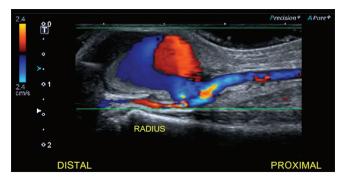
An ultrasound image of the pseudoaneurysm in the longitudinal axis with color Doppler, showing the typical yin-yang sign
